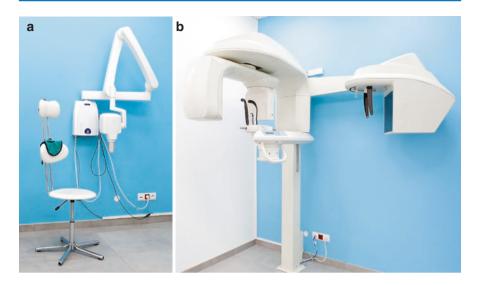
X-ray machines. (a) Intraoral with a dedicated chair for dental X-rays. (b) Panoramic with cephalometric appliance and two digital image detectors
